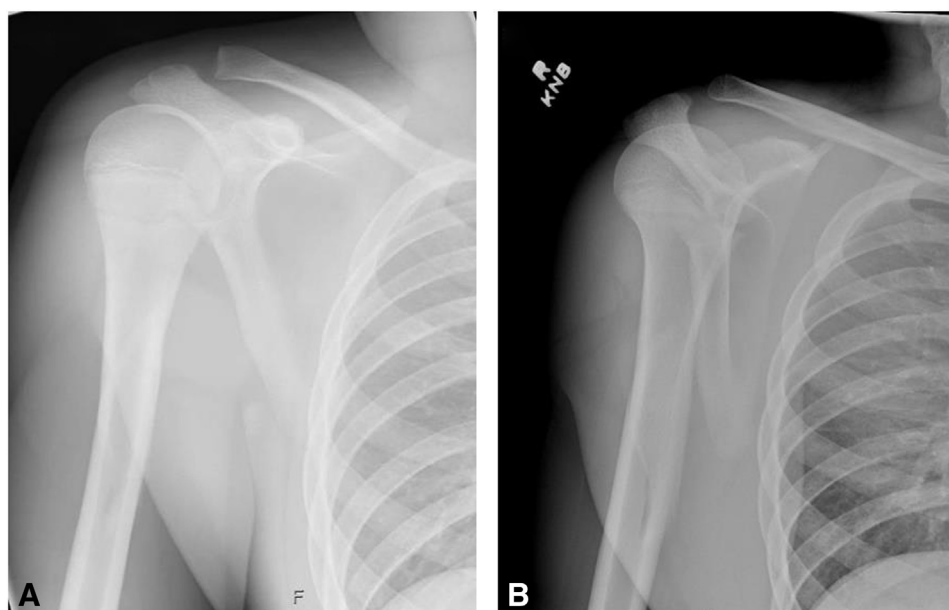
Anteroposterior (A) and scapular Y (B) shoulder radiographs obtained “post-reduction” during the patient’s initial visit to the Emergency Department. A concentrically reduced glenohumeral joint without osseous abnormality or fracture was reported, but careful evaluation at outpatient follow-up demonstrated linear and oblique lines concerning for a humeral shaft fracture.
